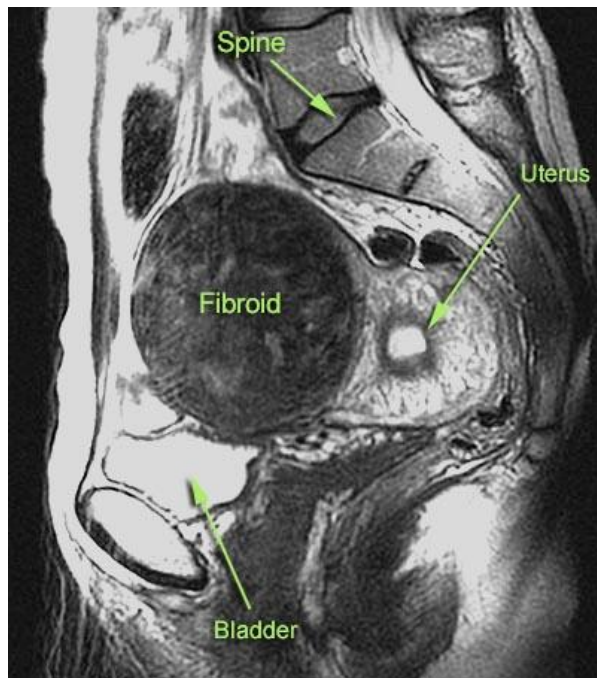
MRI view of fibroid
